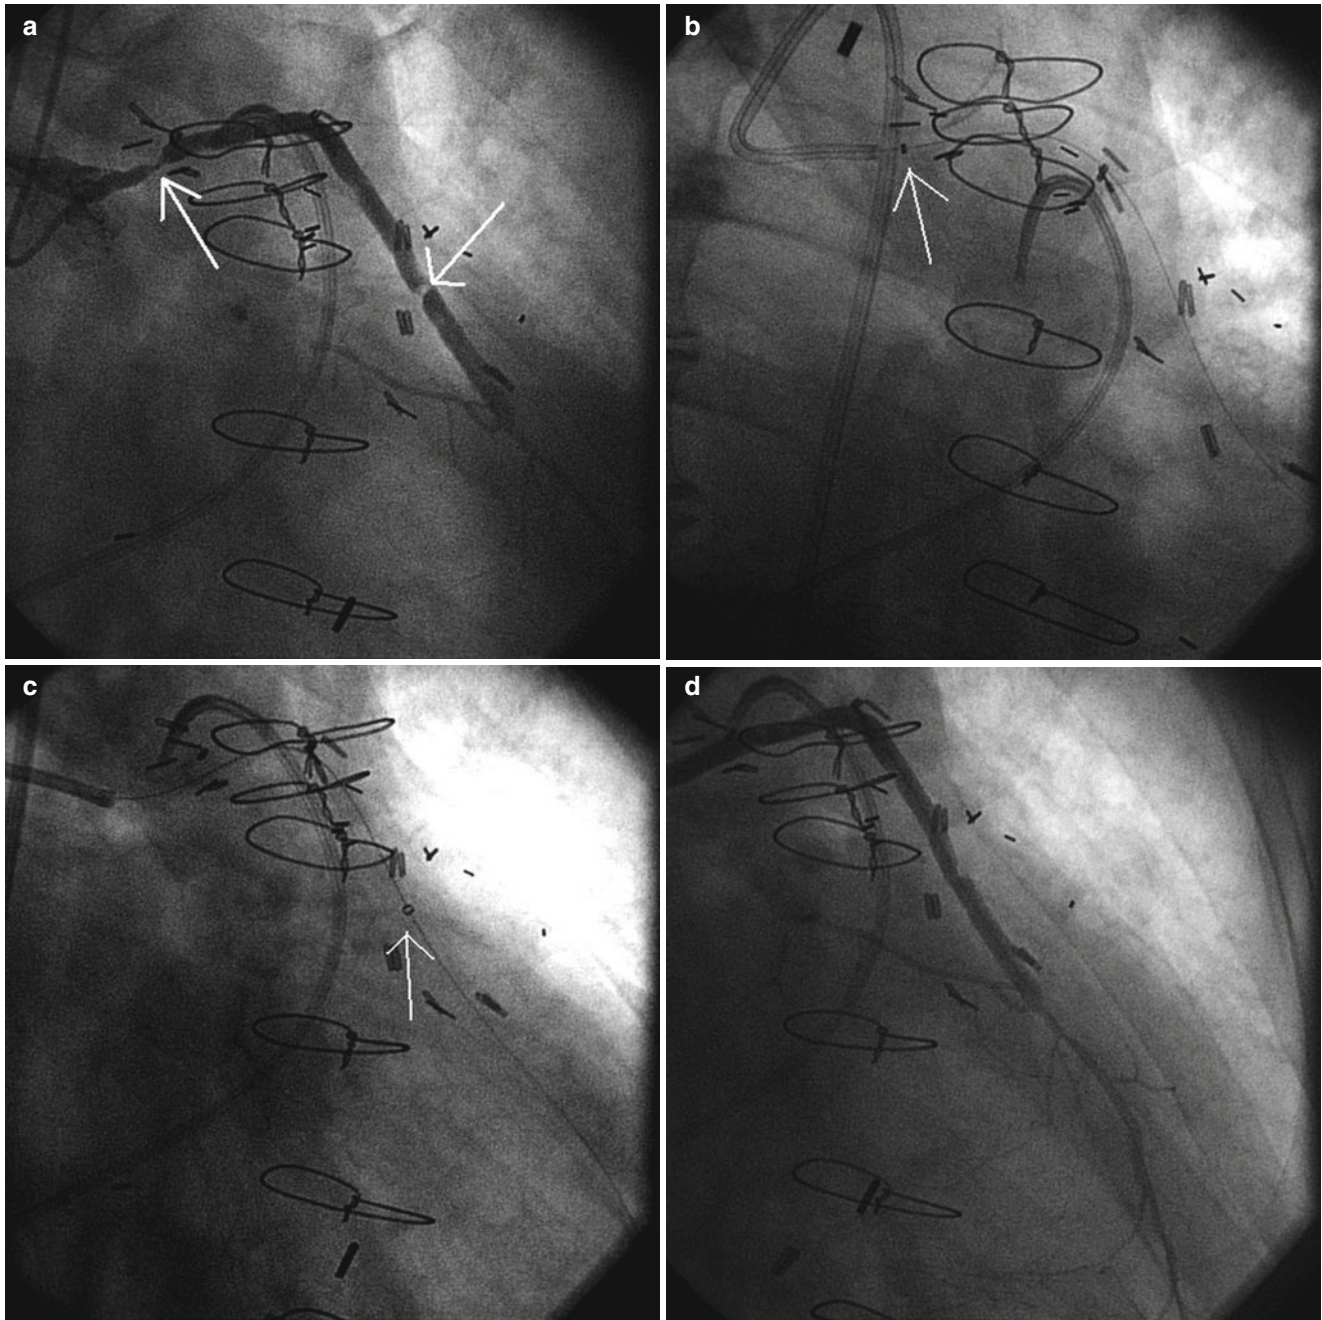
(a) An elderly patient who underwent coronary artery bypass surgery 15 years earlier presented with a large size non STEMI complicated by congestive heart failure and relentless chest pain. Echocardiography demonstrated severely depressed left ventricular ejection fraction. The native coronary vessels were totally occluded and the saphenous vein graft to the LAD was the only remaining vascular conduit. This old bypass graft contained two critical lesions (*white arrows*): proximal 95 % stenosis and middle-distal 99 % eccentric, thrombotic stenosis. The patient had contraindications to the administration of pharmacologic 2b/3a platelets receptor antagonists. (b) A
